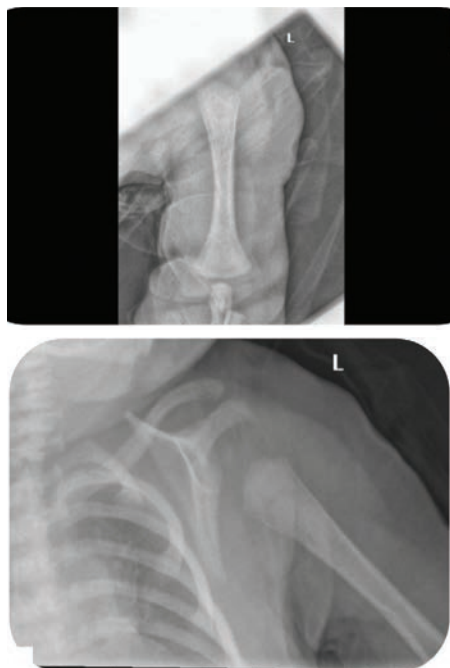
Normal x-ray of the humerus.
